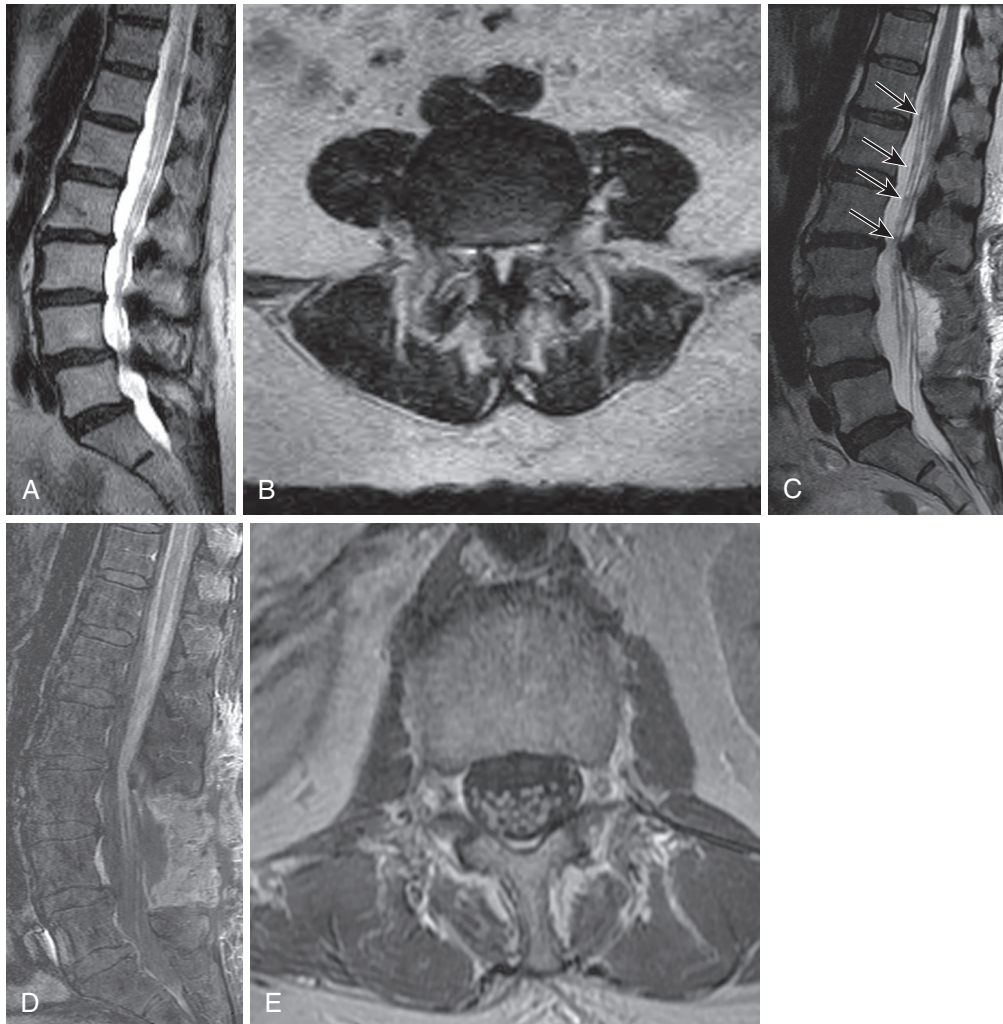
Diminished sensitivity of low field strength upright MRI to sinister lesions. A 74-year-old female presented with bilateral lower extremity weakness and pain with a low field strength upright MRI from another institution. Sagittal T2 image (A) and axial T2 image (B) at the L4 level show degenerative spondylolisthesis at L4 with central canal compromise. She underwent an L3-L5 decompression without change in symptoms. A 1.5 Tesla MRI performed 3 weeks postoperatively demonstrated nodularity (arrows) in the cauda equina on a T2 sagittal image (C). Gadolinium-enhanced fat-saturated T1 sagittal (D) and axial (E) images demonstrate diffuse leptomeningeal metastases from breast cancer. She died in 2 months. A high-quality preoperative MRI would have likely led to the diagnosis and avoided an unnecessary operation. (From Khalil JG, Nassr A, Maus TP. Physiologic imaging of the spine. *Radiol Clin North Am.* 2012;50:599-611.)
